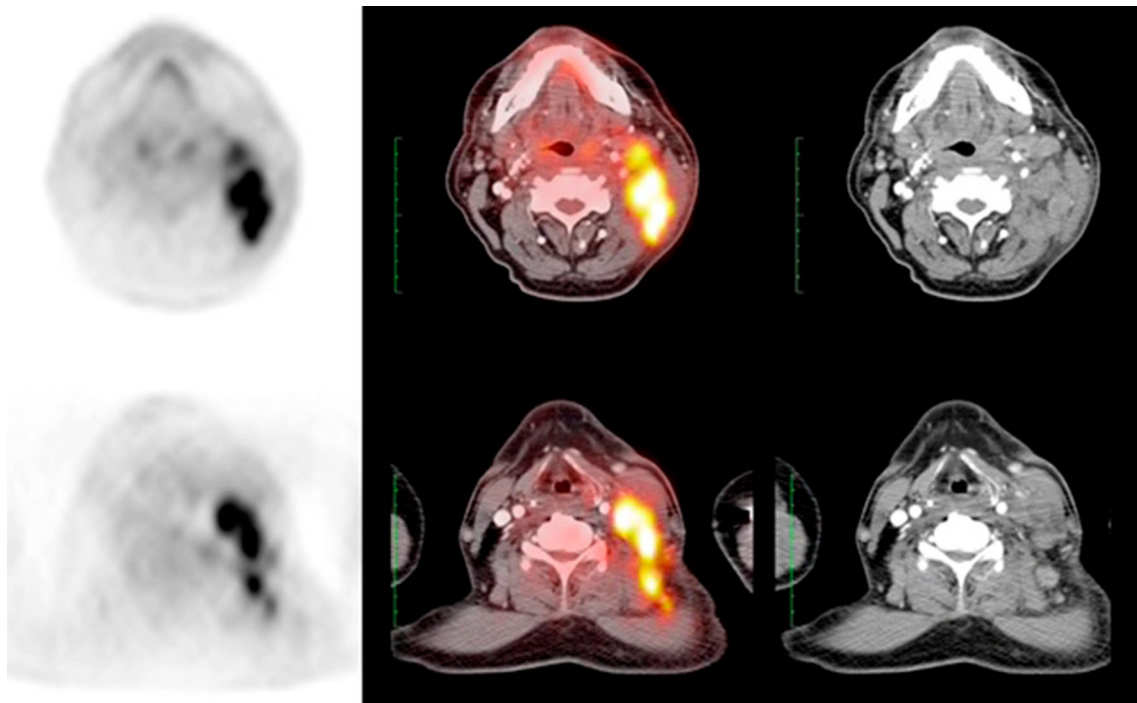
^{18}F -FDG PET/CT shows hypermetabolic lymph nodes in a patient presenting with metastatic cervical lymphadenopathy
